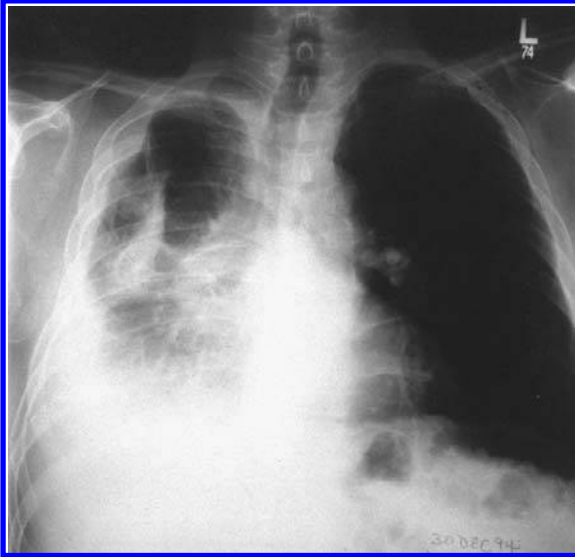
Typical chest radiograph of a patient presenting with shortness of breath and chest pain secondary to a mass in the pleural space.
